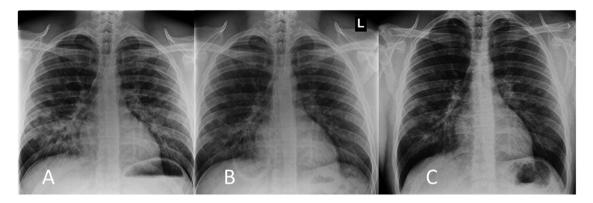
Sequential anterior-posterior chest radiographs of Patient 1, a 23-year-old male, with high-altitude pulmonary edema (HAPE) on (A) day 0, (B) day 1, and (C) day 2.
